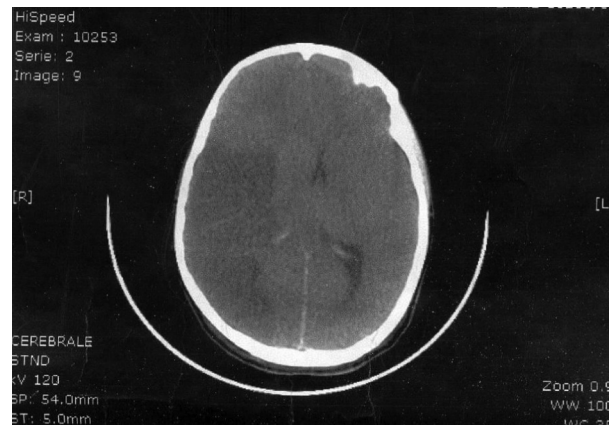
Computed tomographic scan of the brain of case 2 revealing right frontal temporo-parieto-occipital ischemic stroke.
